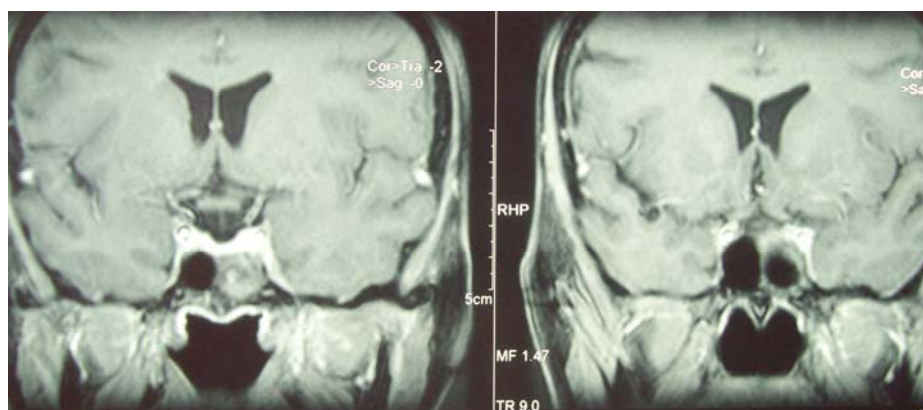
Control magnetic resonance imaging (MRI) focussed on sellar and parasellar region – no progression, no regression [in comparison with the previous finding (Fig. 1)]
